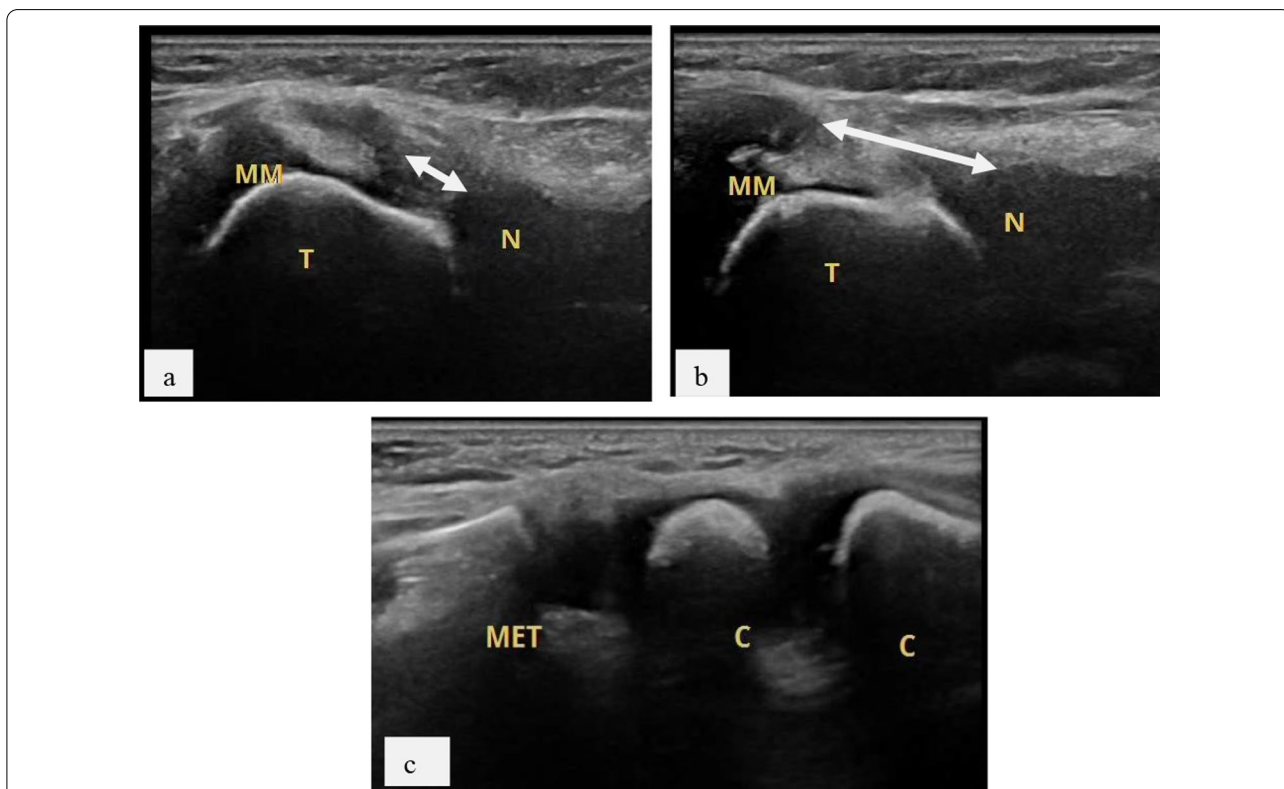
Ultrasound scan dorsal sagittal view of left foot of another 12-day-old male baby, presenting with club foot, showing a decreased MMN distance in dorsiflexion than neutral position. b Increased MMN distance in plantar flexion. c Lateral coronal view of left foot showing angulation of the lateral column. (Met = Metatarsal bone, C = cuboid, C = calcaneus, respectively)
